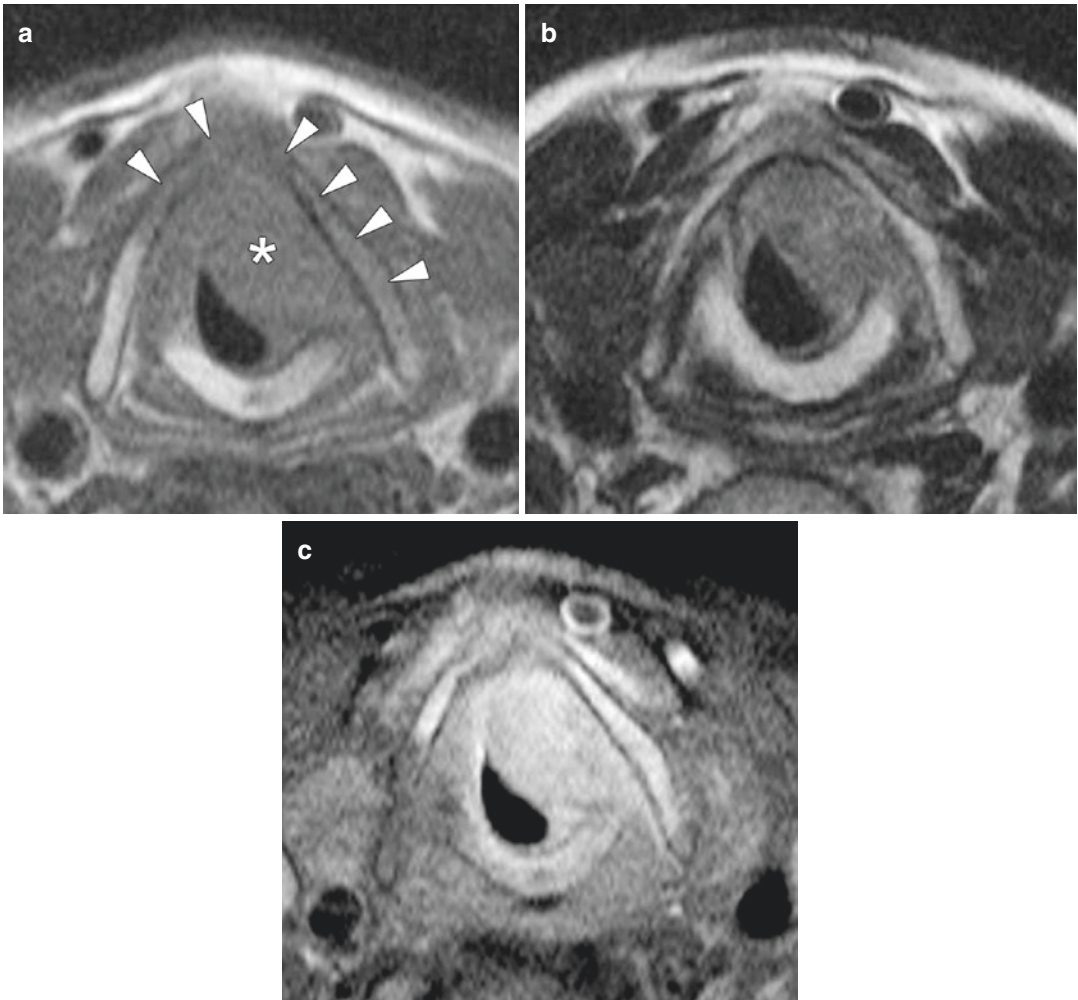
Axial MR images in a patient suffering transglottic cancer. A large soft tissue mass (asterisk) is seen, centered on the left glottis/subglottis, extending over the midline. On the T1-weighted spin echo image (a), signal loss is seen in the adjacent part of the thyroid cartilage (arrowheads). On the T2-weighted image (b) the tumor shows a lower signal
